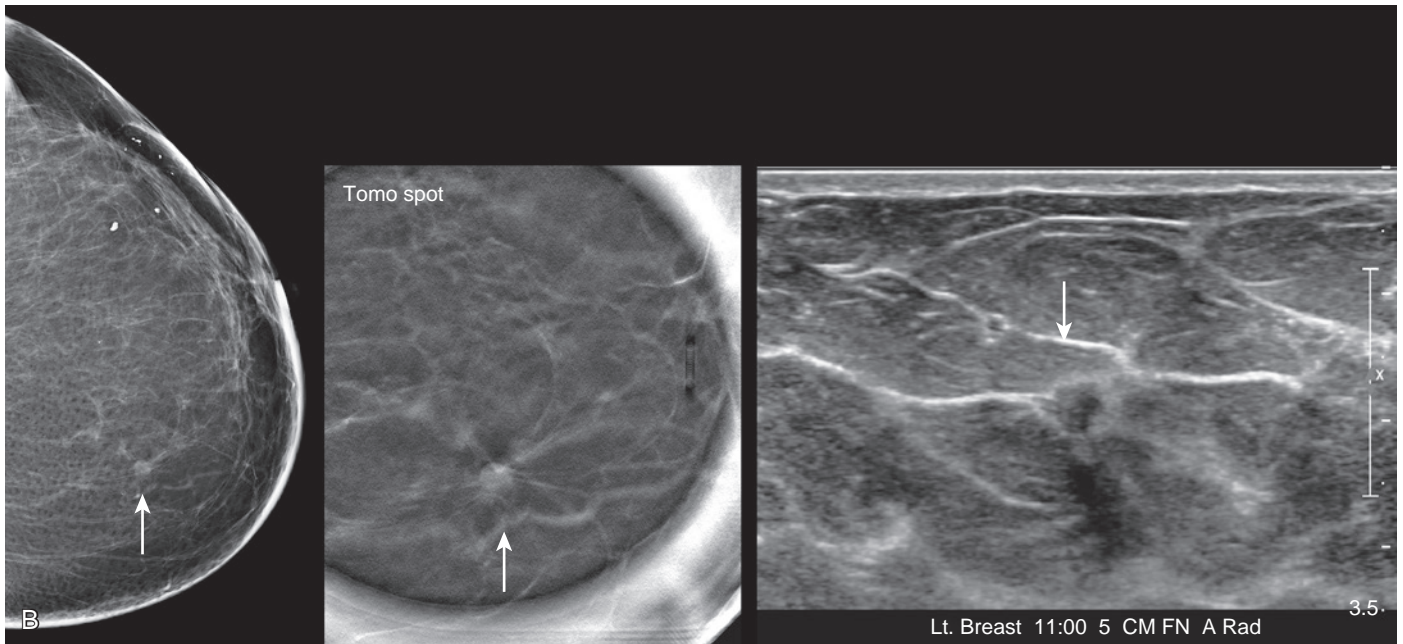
Second primary (two examples). Case 1: (A) 64-year-old woman is 14-year status post–node-positive invasive breast cancer, lumpectomy, and radiotherapy. Minimal scarring is present in the lateral breast. (B) One year later there is a new small mass (*arrows*) in the medial breast, with spiculated margins appreciated on a craniocaudal spot compression tomosynthesis slice. A corresponding small irregular hypoechoic mass with an echogenic boundary is identified by ultrasound. Diagnosis is invasive lobular carcinoma, ER/PR+, Her2–. Case 2: (C) A 54-year-old woman is 21-year status-post node-positive retroareolar invasive ductal carcinoma, lumpectomy, and radiotherapy. There is postsurgical scarring with dystrophic calcifications in the central breast. (D) Two year later a new asymmetry is seen in the medial breast. Tomosynthesis shows a suspicious mass with irregular shape and spiculated margins (*white arrow*), as well as a second suspicious mass further medially (*black arrow*). Magnetic resonance imaging demonstrates two corresponding enhancing spiculated masses (*white and black arrows*). Diagnosis is invasive ductal carcinoma, moderately differentiated, ER/PR+, Her2–.
